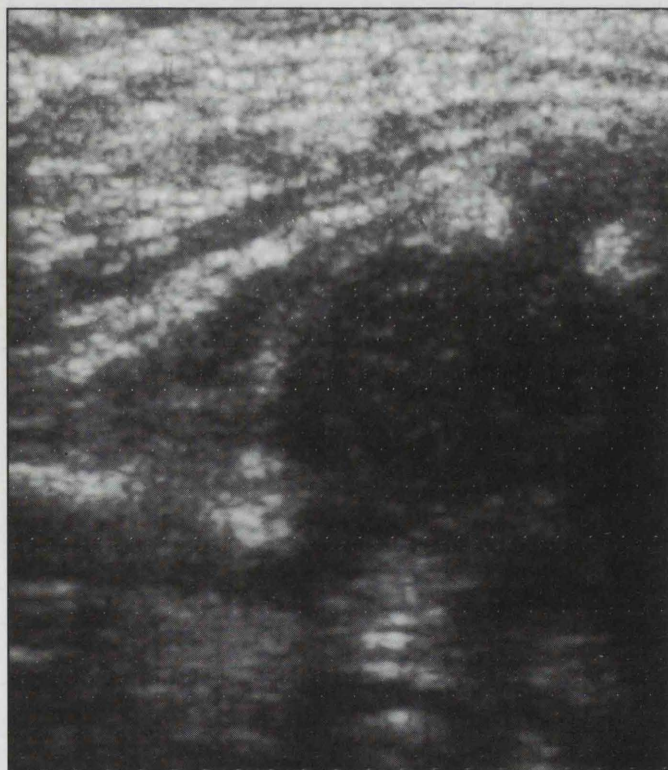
Ultrasound examination of a dislocated hip. Note that there is no 'wineglass' acetabulum adjacent to the femoral head
